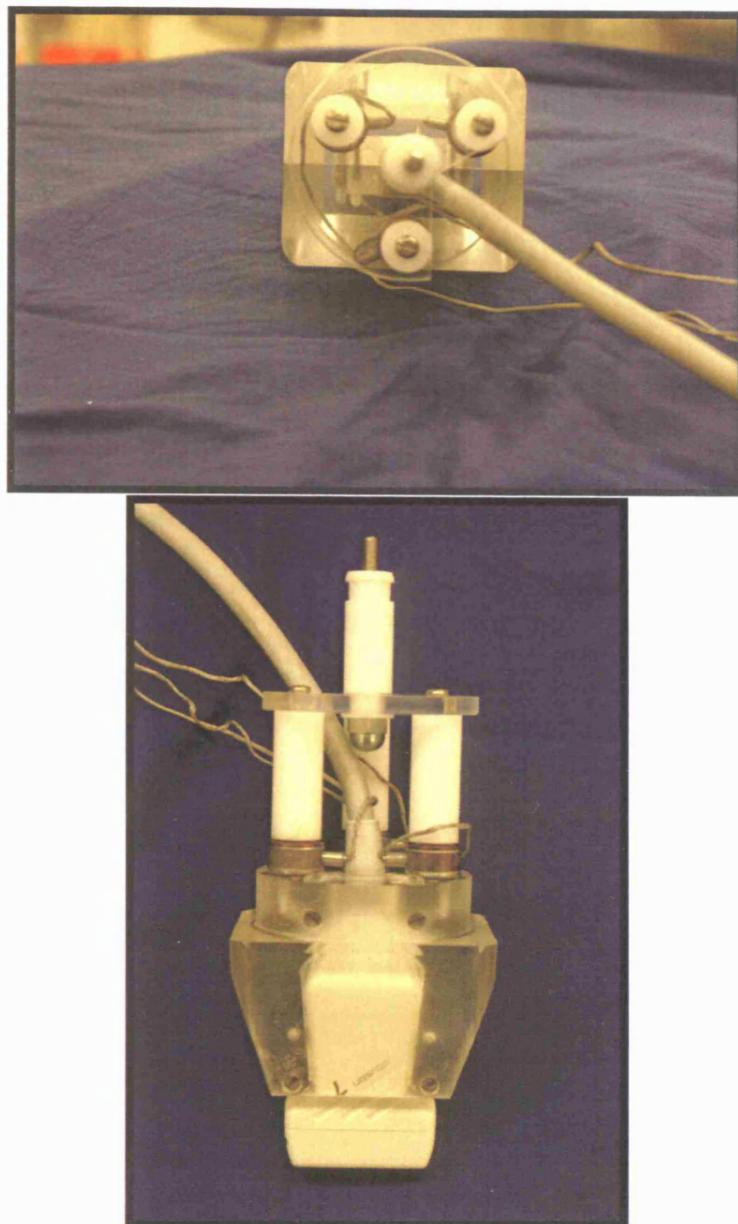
The L7 ultrasound probe with purpose-built platform housing 3 load cells forming an equilateral triangle
